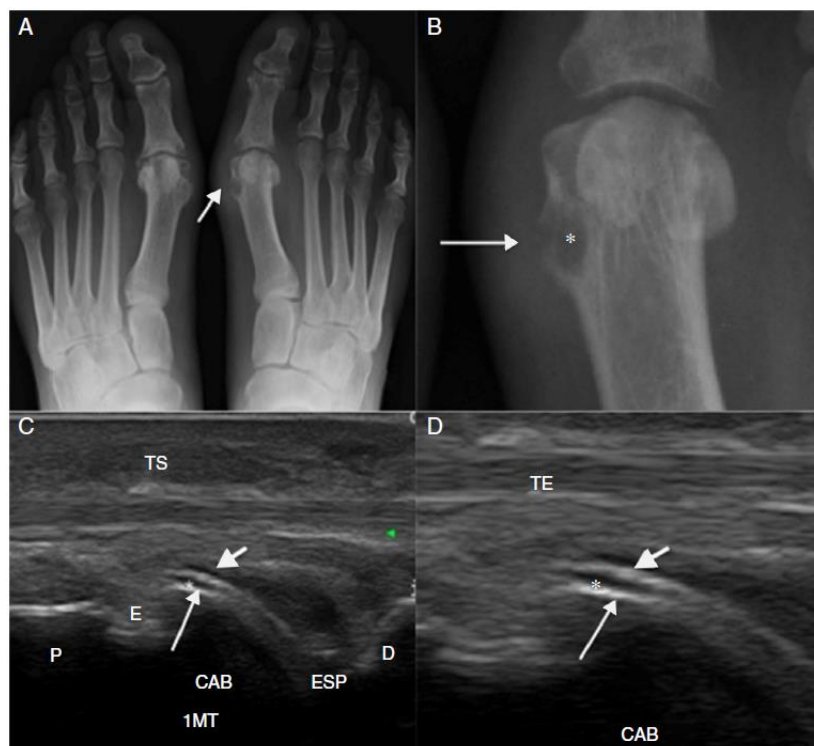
A: anteroposterior radiograph of the feet of a patient with gout showing increased volume and soft tissue density adjacent to the 1^a MTF joint (arrow). Bone erosion is also noted in the distal metaphysis of the 1st metatarsal; B: detail of the previous image showing the head of the 1st left metatarsal, evidence of bone erosion marked with an asterisk (*) with raised borders and Martel’s reaction (arrow); C: ultrasound image with longitudinal section of the foot at the level of the 1st metatarsophalangeal joint of the 1st toe, showing the bony cortical bone of the 1st metatarsal head (larger arrow), the metatarsophalangeal joint space of the hallux (ESP), the cartilage of the 1st metatarsal head (*) and a thin hyperechoic layer covering the lining cartilage (smaller arrow), characterize the double contour sign; D: detail of the previous image showing the bone surface (arrow) of the 1st metatarsal head, the articular cartilage (*) and the thin hyperechoic layer (setamenor), characterizing the double contour sign (P–proximal, D–distal, TS–subcutaneous tissue, ESP–phalangeal hallux, TE–extensor hallucis tendon).
